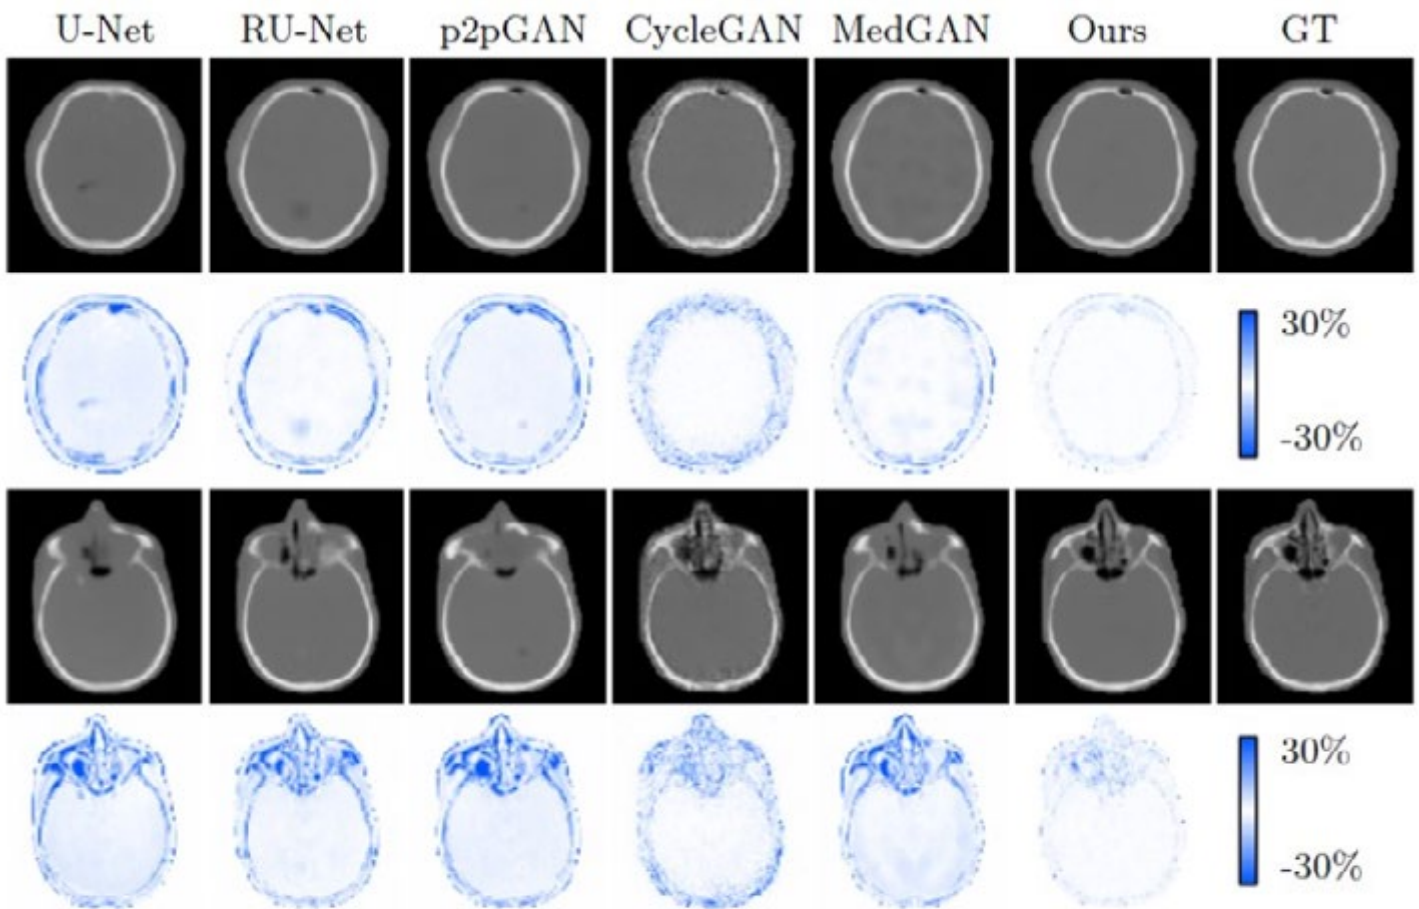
Visual comparison of synthesized CT images by different methods on two typical samples. For each sample, the first row shows CT images, and the second row shows the corresponding error maps.
